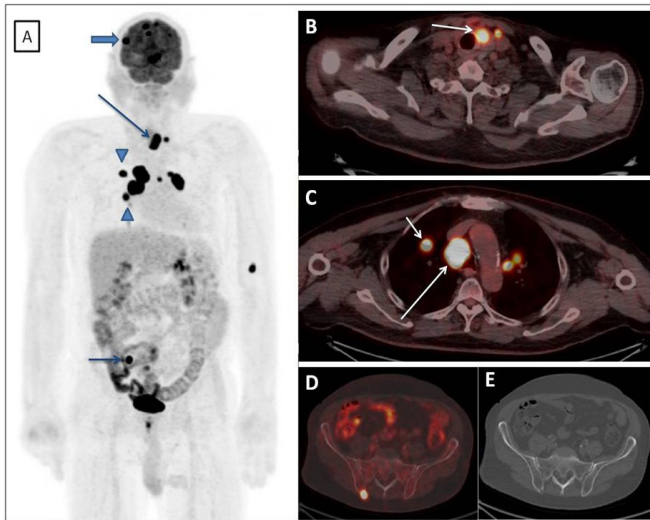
Maximum intensity projection (MIP) image (A), showing intense FDG uptakes in residual tumor (long arrow), multiple brain metastases (thick arrow), cervical, mediastinal and hilar lymph nodes (SUVmax:57.3), lung nodules (SUVmax:23.6) (arrow heads), and right iliac metastasis (SUVmax:30.0) (thin arrow). FDG PET/CT fusion image (B) showing focal FDG uptake in isthmus localization (SUVmax:22.9) (arrow) and left cervical metastatic lymph node. FDG PET/CT fusion image (C) showing focal FDG uptake in right lung nodule (short arrow), right paraaortic (SUVmax:56.9) (long arrow) and left hilar lymph nodes. FDG PET/CT fusion (D) and corresponding CT (E) images showing focal FDG uptake of lytic bone metastasis in posterior right iliac bone.
